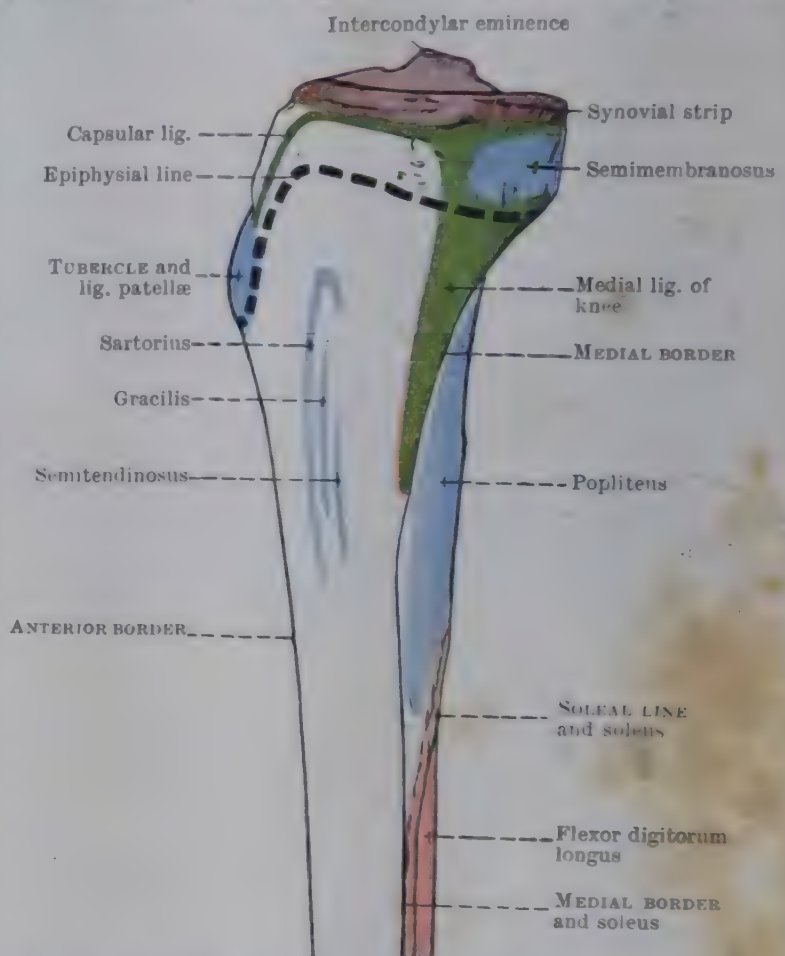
MEDIAL ASPECT OF UPPER HALF OF RIGHT TIBIA.
